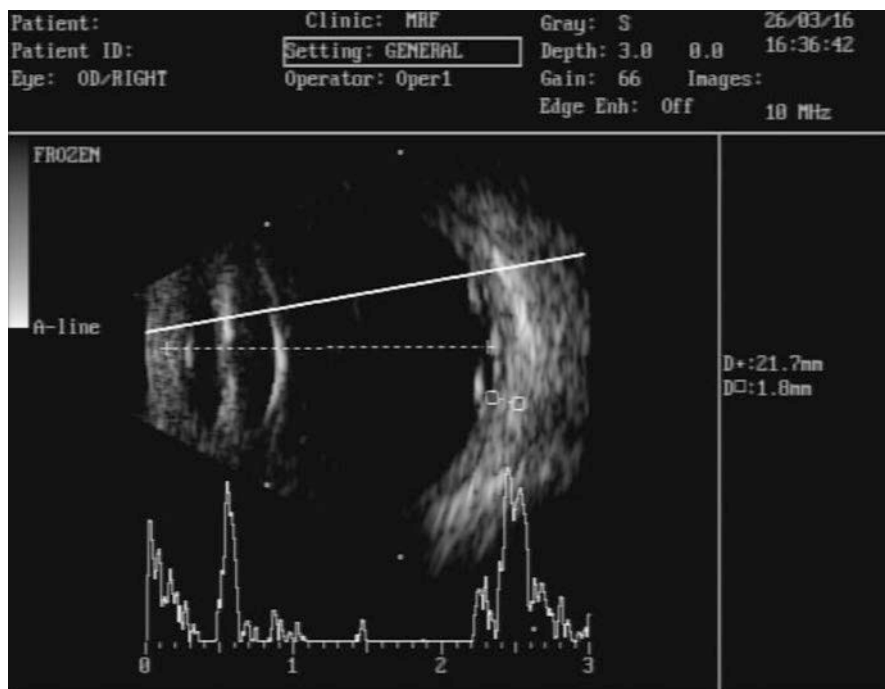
Ultrasound B-scan of right eye of a patient with VKH showing multiple pockets of subretinal fluid with diffuse choroidal thickening
